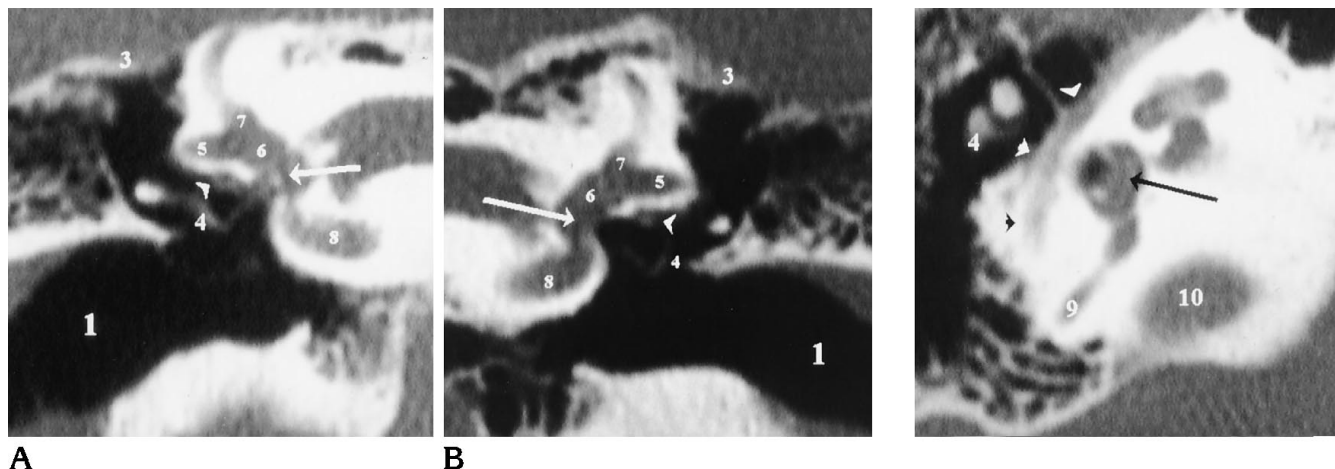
High-resolution coronal CT scans of the oval window.
